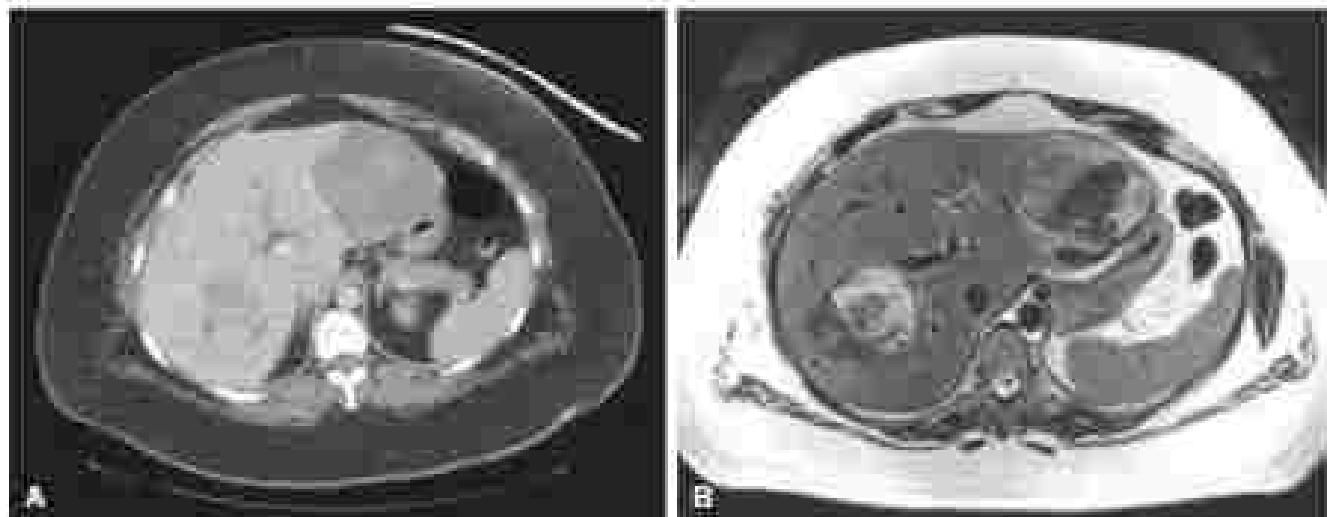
(A) Axial computed tomography image of a 31-year-old female patient with a large, well-circumscribed, hypodense liver lesion, consistent with a hemangioma. (B) Axial CT-weighted image of the same patient showing a small, hyperdense, enhancing nodule, consistent with a hemangioma.
